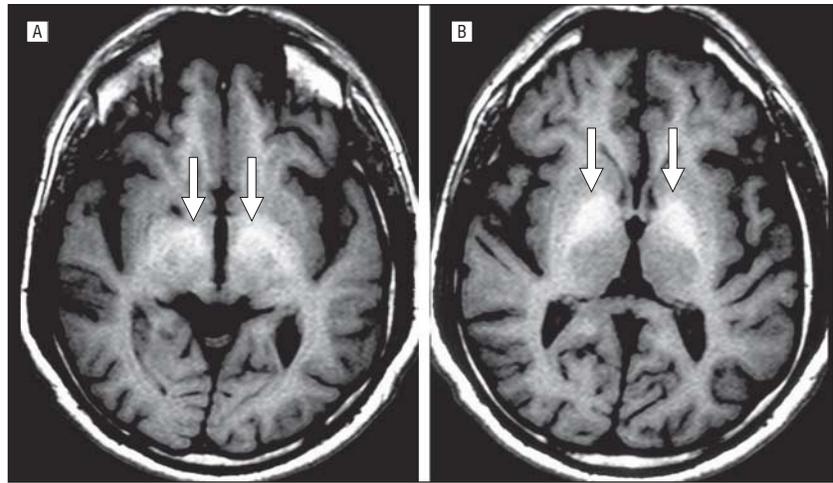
Axial T1-weighted images show bilateral and symmetric hyperintensities within the subthalamic region (A) and the globus pallidus (B) (arrows).
